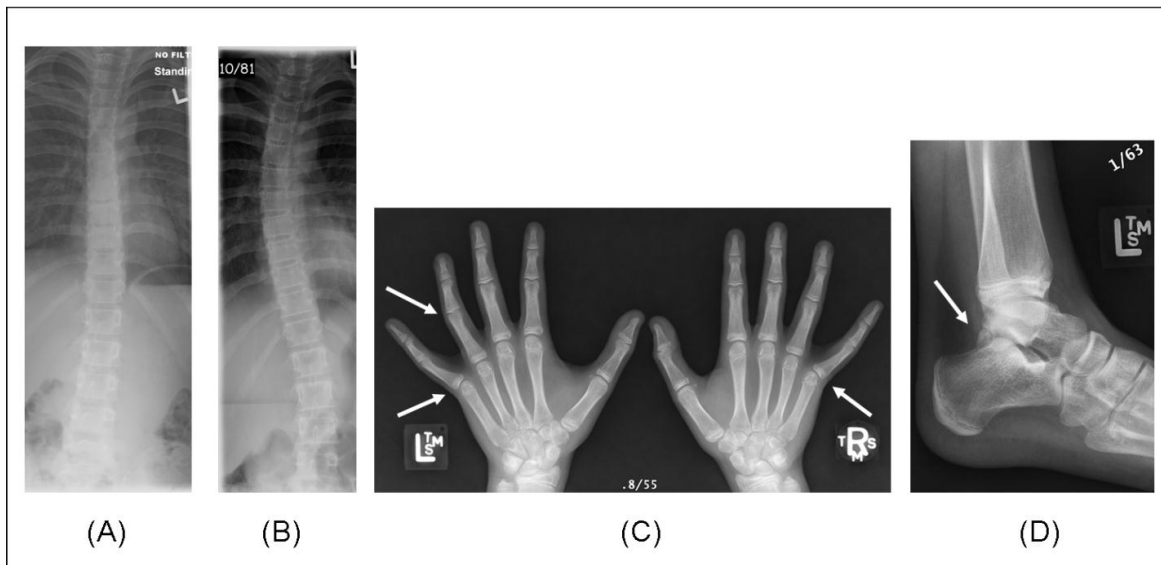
A and B, spine radiographs at 10 and 14 years of age, respectively, showing scoliosis that increased with age. C, hand radiographs (arrows indicate flexion of the left 4th proximal interphalangeal joint and lateral abduction of both 5th digits at the metacarpophalangeal joints) and D, left ankle radiograph (arrow indicates os trigonum) at 14 years of age.
